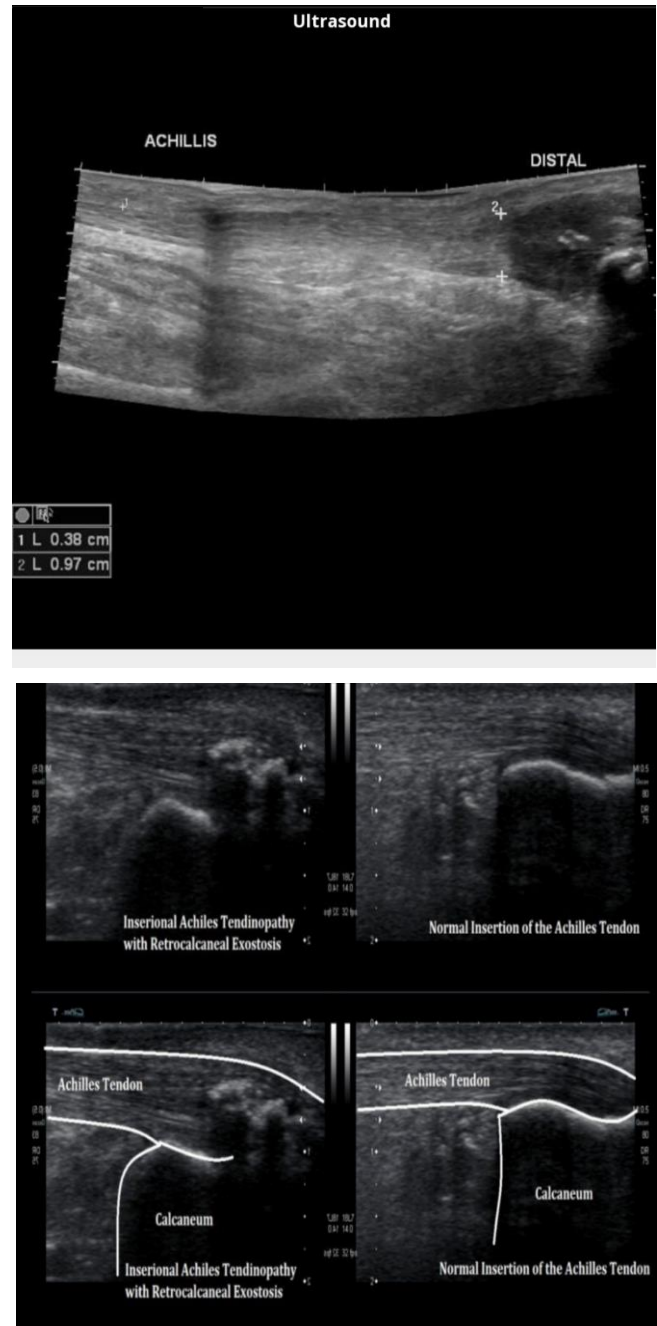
In the above image, ultrasound imaging of insertional Achilles Tendinopathy
